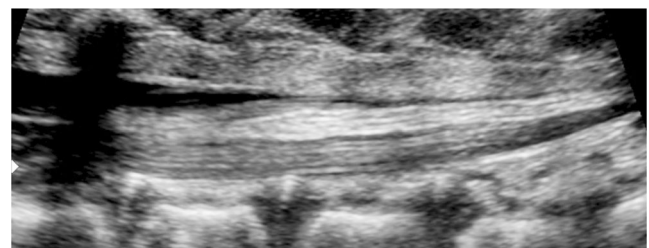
Sonogram of a 2-week-old boy shows a fatty filum
